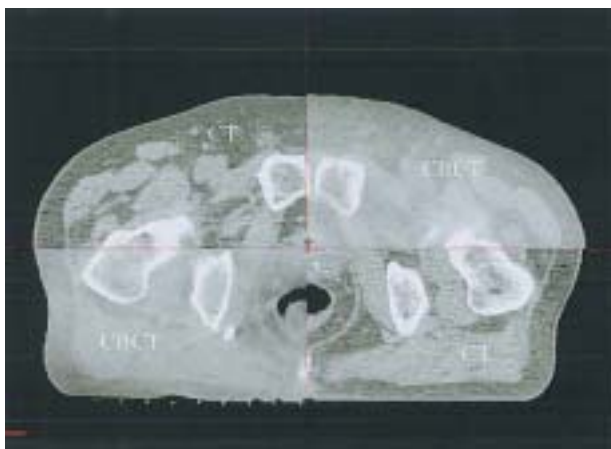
The fusion of the 2 types of CT and CBCT images for a prostate case.
